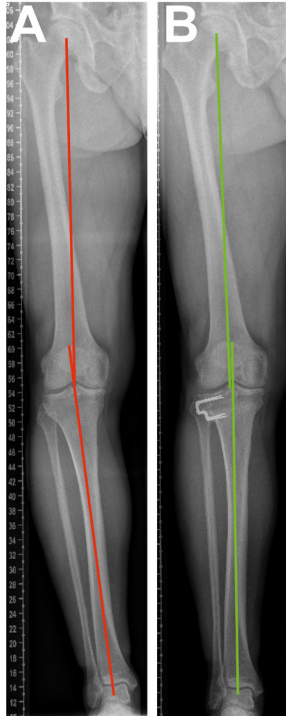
Radiographs taken before and after lateral closing-wedge HTO
